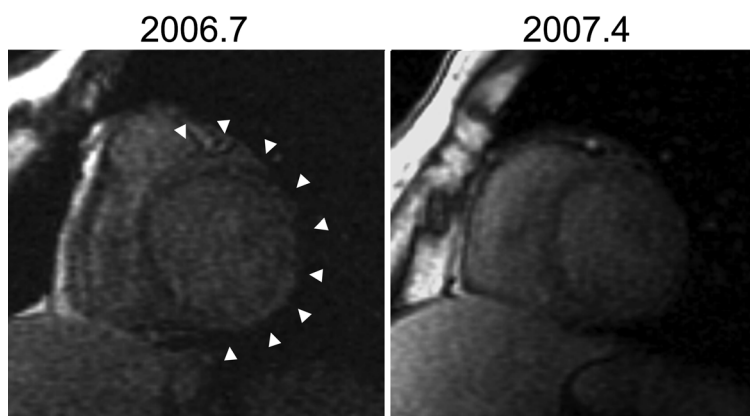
MRI with gadolinium showed late enhancement of the midwall and subepicardium in the anteroseptal, lateral, and posterior walls of LV (arrow heads), and this change decreased about 10 months after the first MRI.
